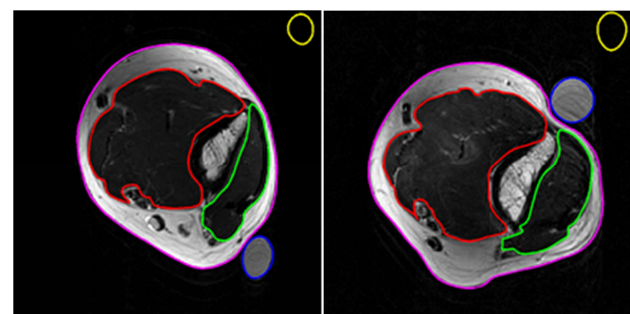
Baseline (left) and day 2 (right) MRI images for subject in HFHR condition. Elbow flexors are outlined in red and elbow extensors are outlined in green. Note increased signal intensity in elbow flexors on day 2 (indicative of inflammation).
